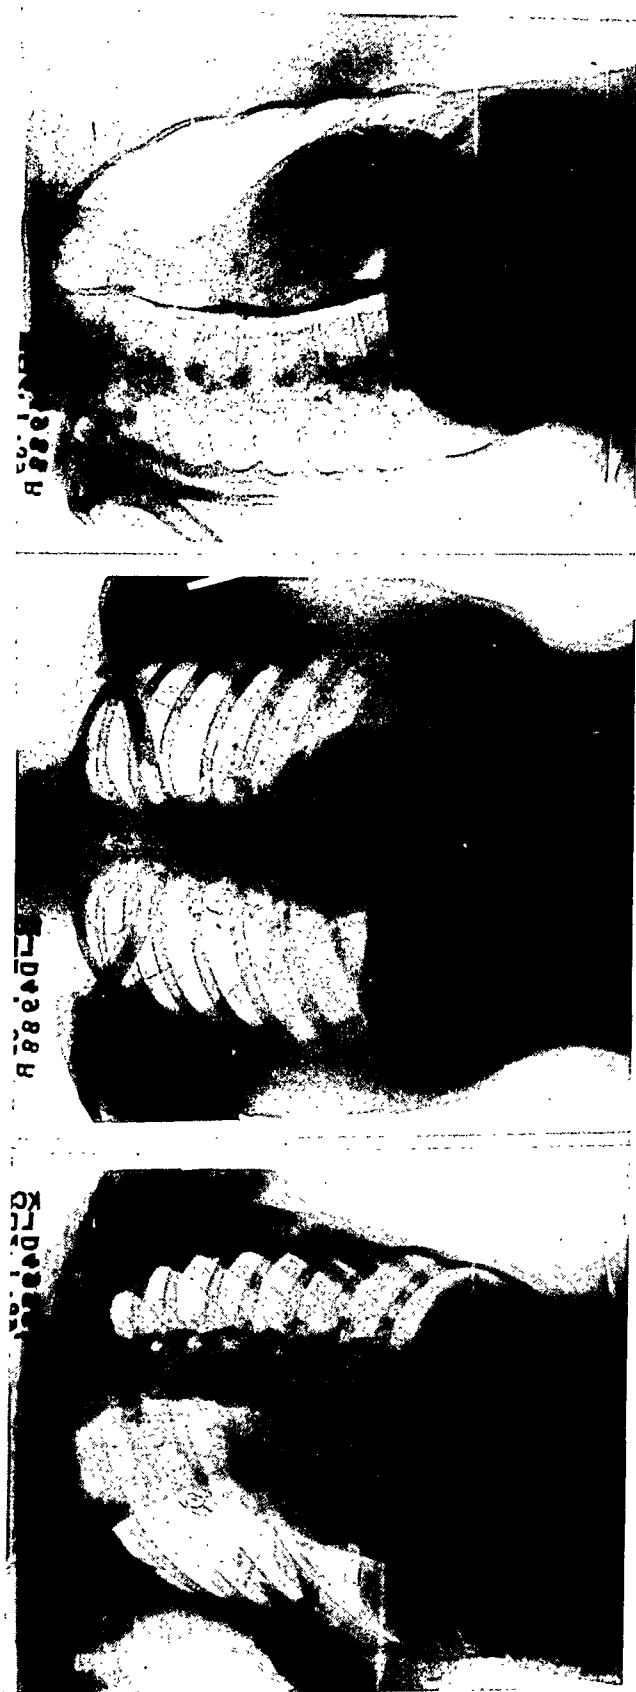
Roentgenograms of Patient A. G., Case 9. Patient ten weeks pregnant.
